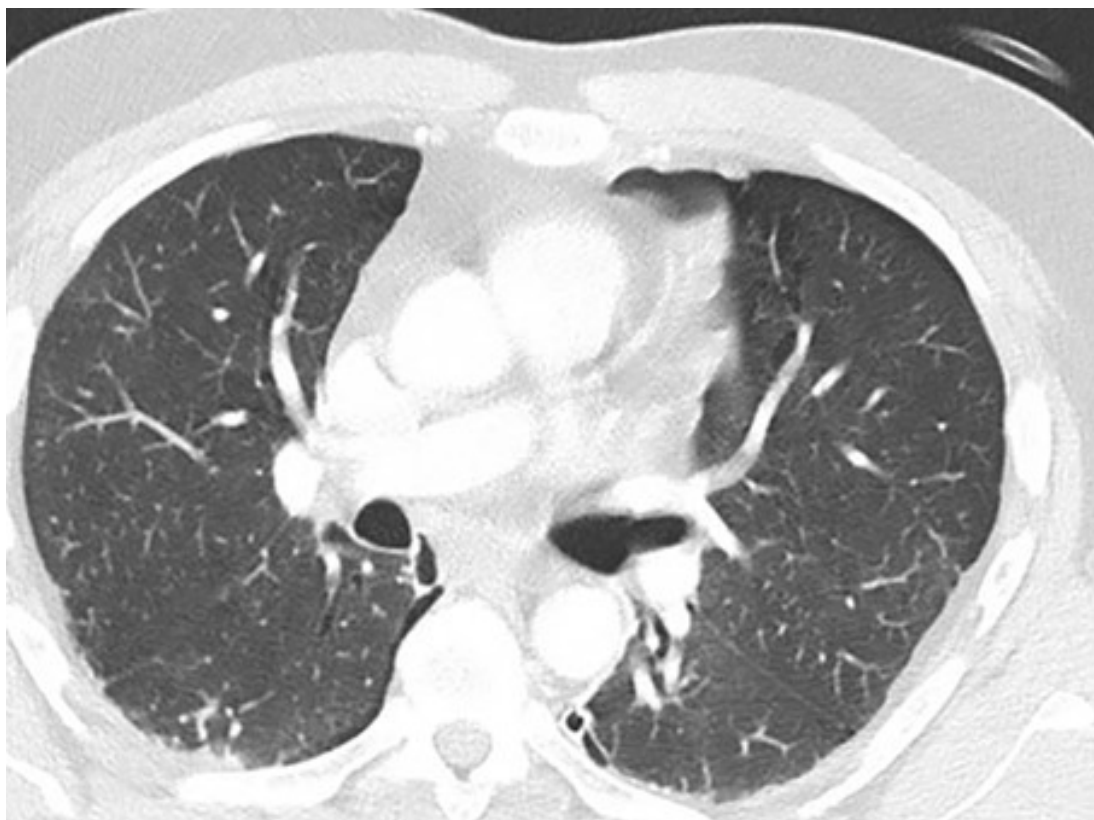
Chest CT with injury site.
